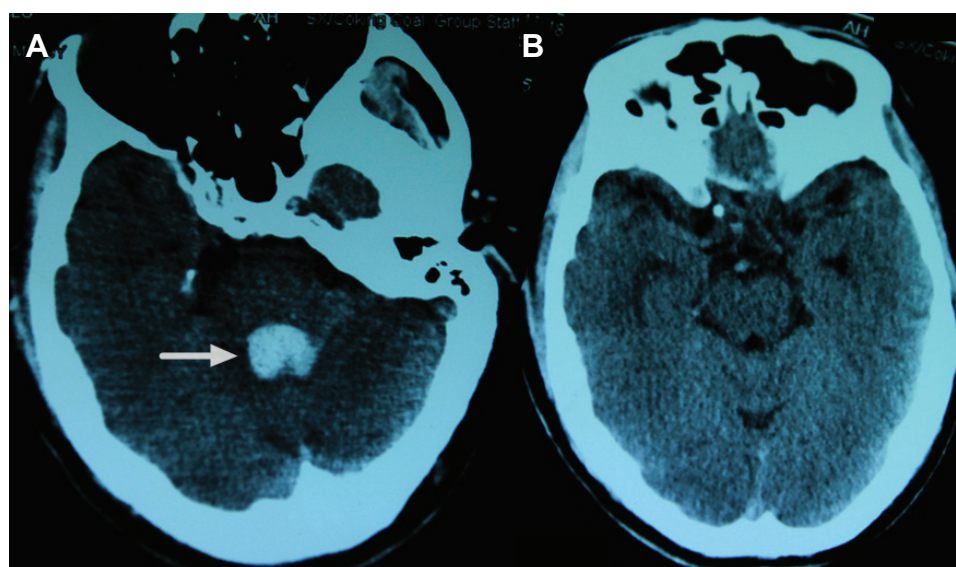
Brain computed tomography (CT) scan showing brain stem hemorrhage preoperatively (arrow) (A), and postoperative CT brain images (B).
